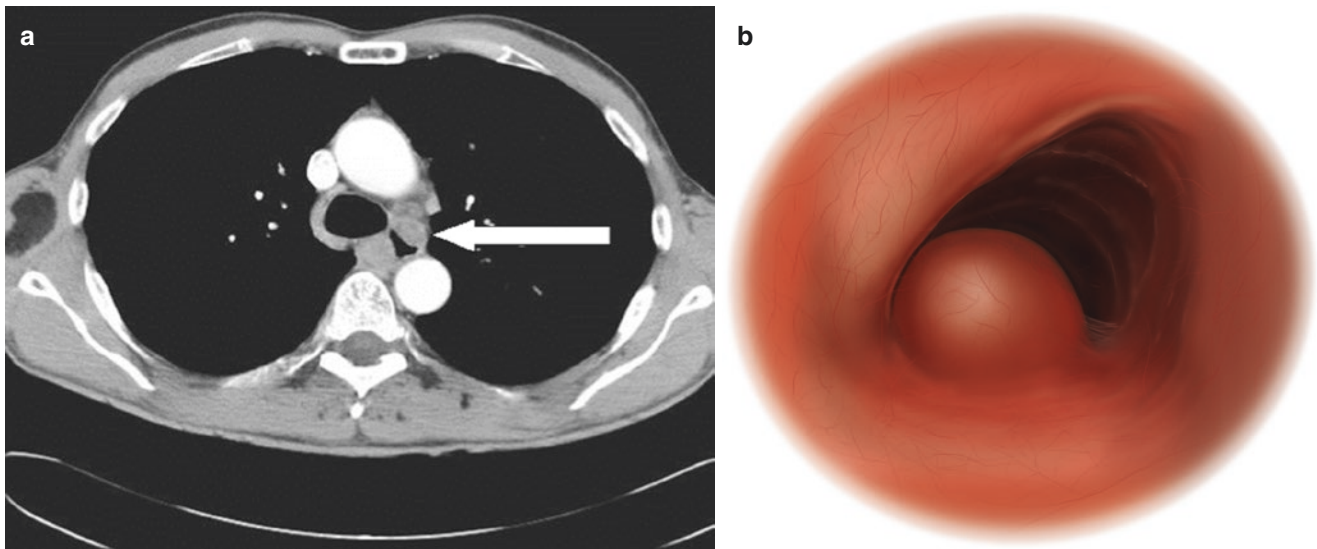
Picture of endoluminal (a) and CT (b) view of the lesion
